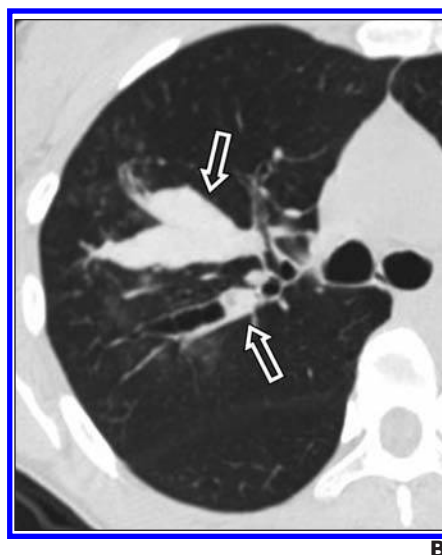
Allergic bronchopulmonary aspergillosis. A, Posteroanterior chest radiograph shows right-sided tubular perihilar opacities (gloved finger sign) (arrows) as well as increased intercostal spaces indicating overinflation.
